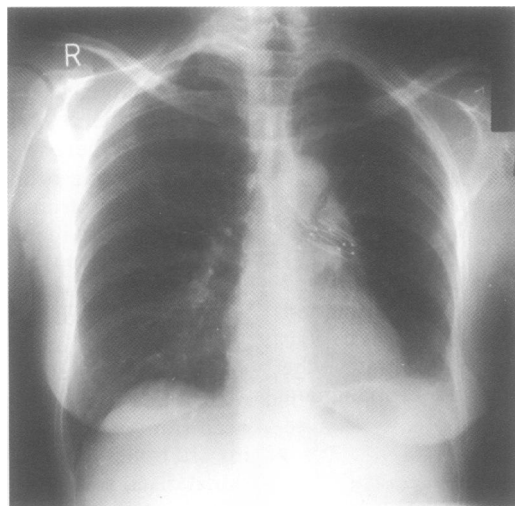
Chest radiograph showing stent in situ three months after insertion.
